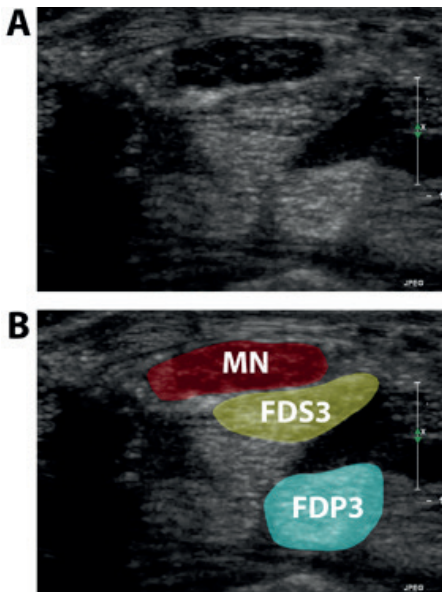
A. A transverse plane ultrasound image at the carpal tunnel inlet of a CTS patient during extension of all fingers. B. Manually placed polygons on the outside border of the MN, FDS3 tendon and FDP3 tendon.
